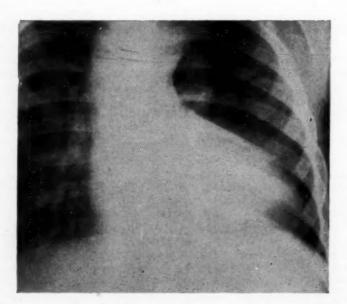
Case 4. A 6-foot posteroanterior chest radiograph. There is considerable cardiac enlargement and a prominent aorta. The left middle third of the heart shadow is concave and the main pulmonary artery cannot be distinguished. The left main branch cannot be identified with certainty but there is a vascular shadow at the left hilum. The lungs are oligemic.
